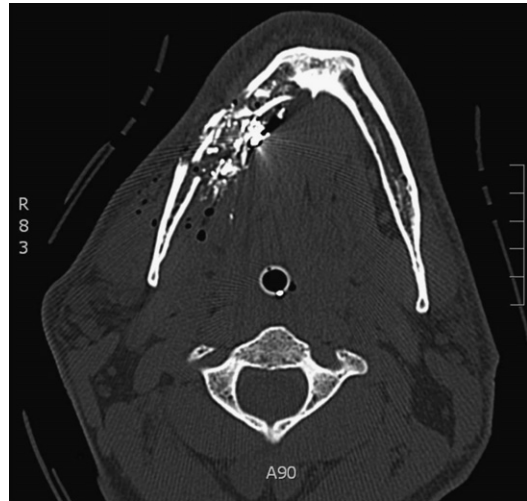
Axial CT shows extensive fragmentation of right mandibular body from patient in Fig. 8.
